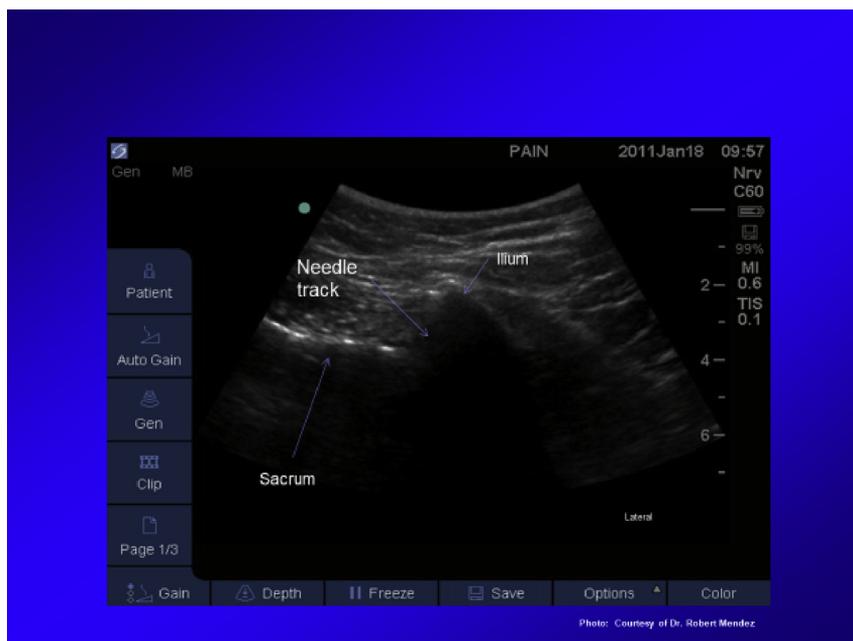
Ultrasound-guided SI joint injection.
